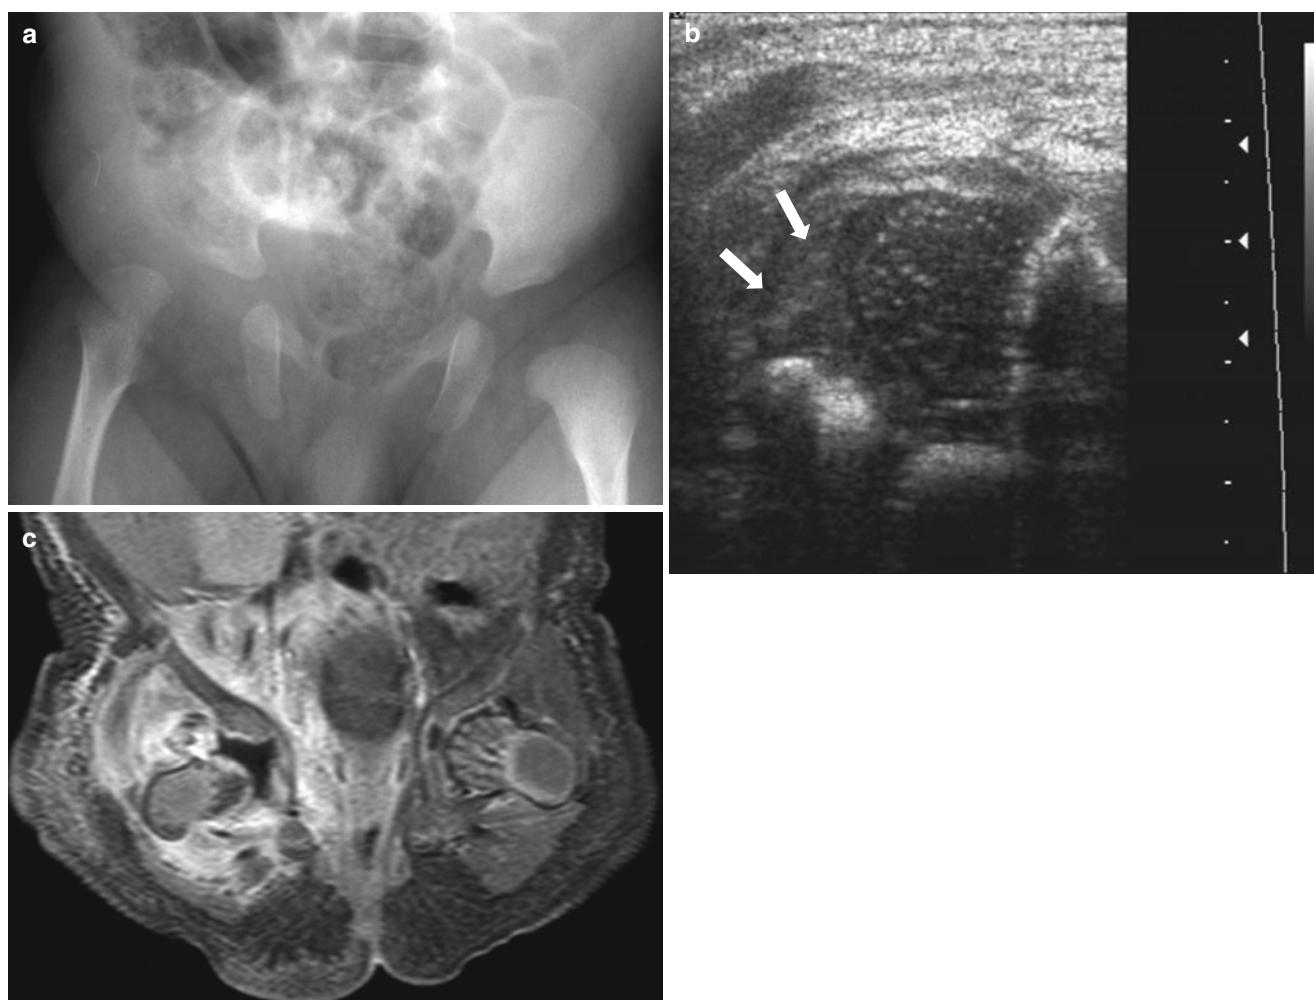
Neonatal septic arthritis of the hip. (a) Anteroposterior radiograph of a neonate with painful swelling of the right proximal thigh shows superolateral displacement of the proximal femur. (b) Transverse view of right hip ultrasonogram shows ill-defined heterogeneous
